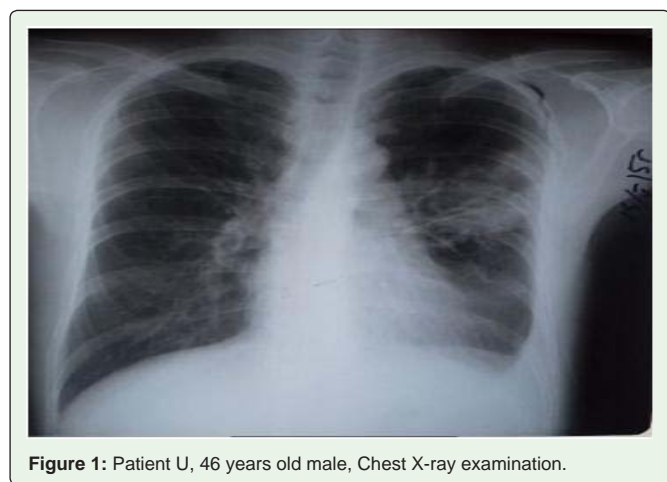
Patient U, 46 years old male, Chest X-ray examination.
